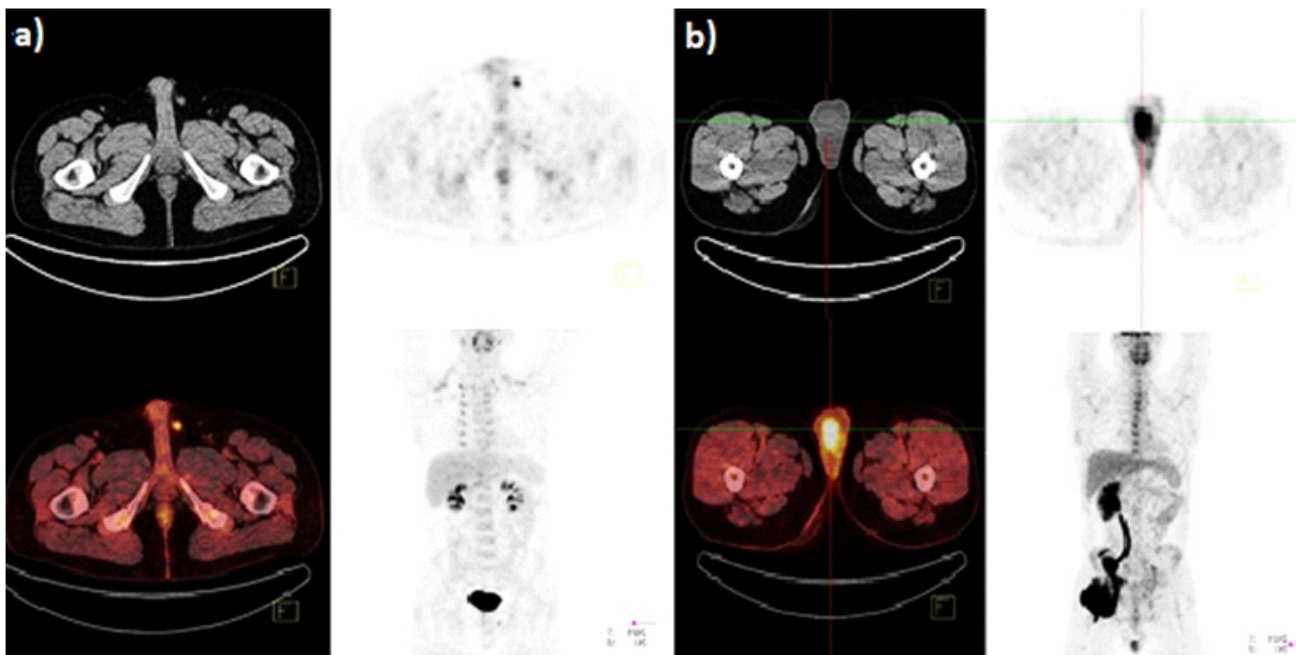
Axial CT, PET and PET/CT images and MIP (maximal intensity projection): Local recurrence of seminoma in: a) surgically removed left testicle (SUVmax 4.6); b) contralateral testicle (SUVmax 5.1).
